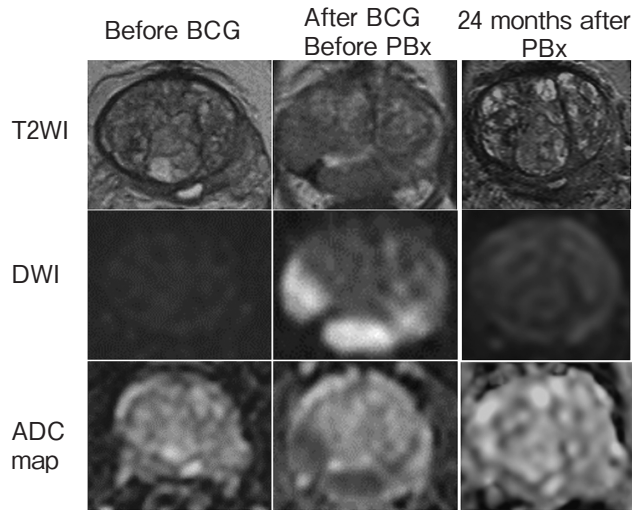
MRI of a representative case showing temporal changes. A *de novo* low-ADC lesion, which was not detected before BCG treatment, appeared 3 months after the completion of the BCG treatment. A subsequent biopsy detected a BCG granuloma, with no malignant findings. These lesions had disappeared 24 months later.
